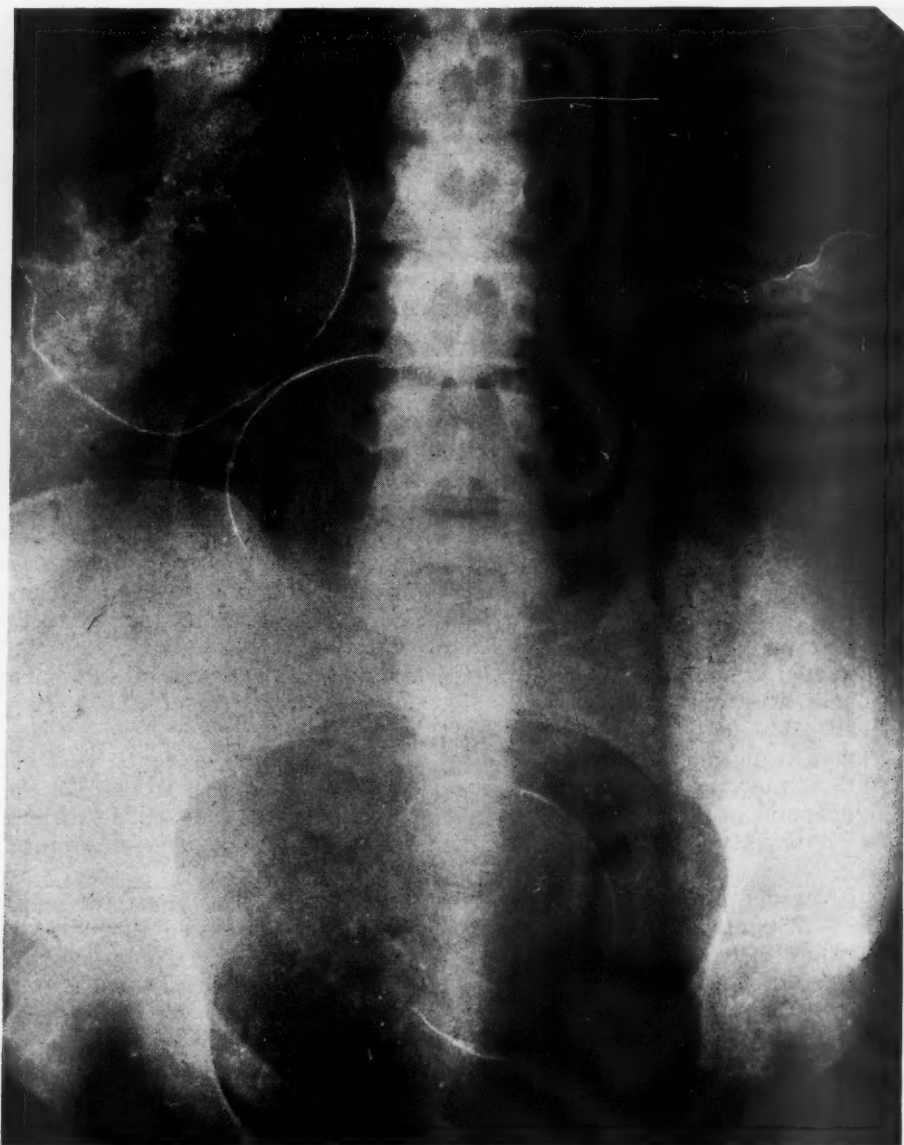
Radiograph of pelvis showing four fetal heads. The outlines of the heads have been slightly strengthened by retouching in order to make them visible in the half-tone reproduction (reduced).
